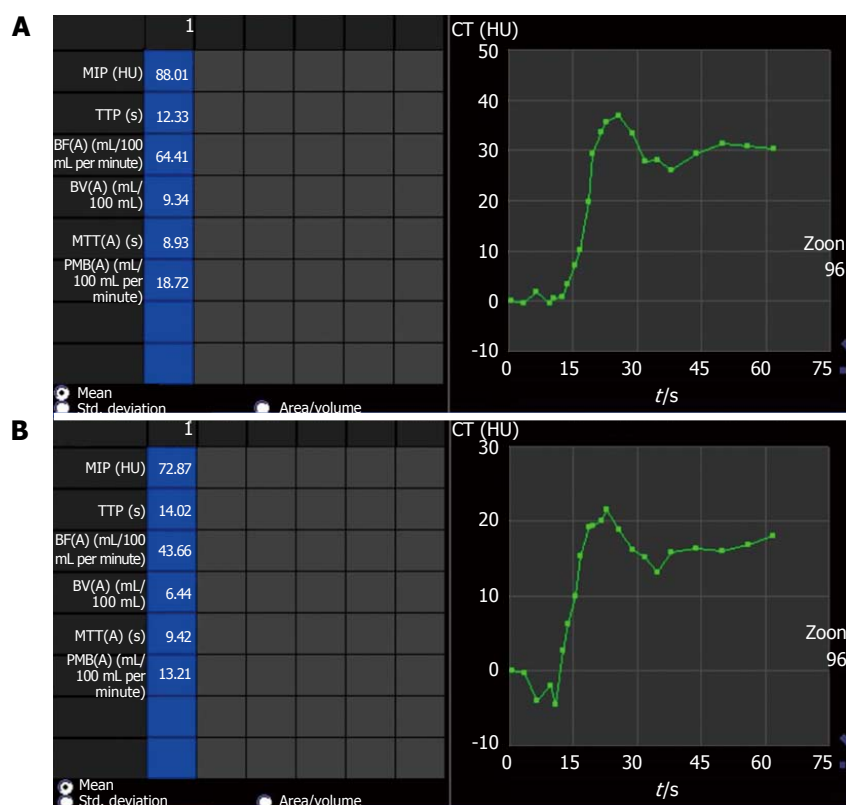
Perfusion parameters showing partial response with anti-angiogenic therapy. Comparison of perfusion parameters in right side chromophobe renal cell carcinoma (same patient as shown in Figure 2) after start of anti-angiogenic therapy shows partial response as permeability (PMB) in follow-up scan (B) at 6 mo interval decreased compared to baseline scan (A). The PMB measured 18.72 mL/100 mL per minute at baseline (A) while in follow-up scan (B), PMB was 13.2 mL/100 mL per minute. There was no interval change in lesion size and would have been labeled as stable disease in absence of perfusion parameters. MIP: Maximum peak intensity; TTP: Time to peak; BF: Blood flow; BV: Blood volume; MTT: Mean transit time; CT: Computed tomography.
